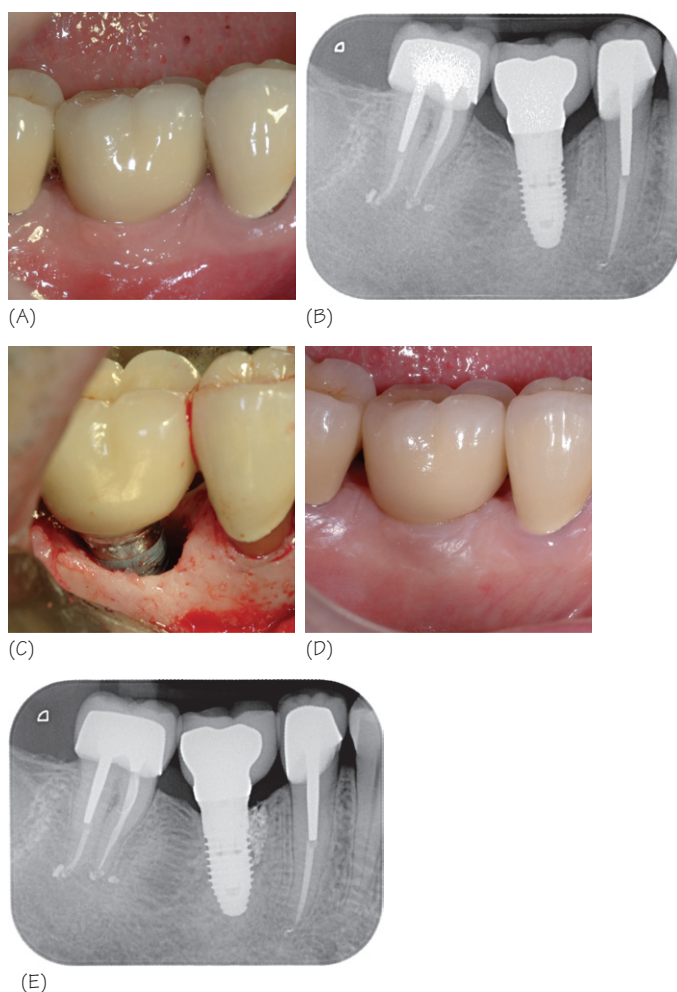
Radiographic interpretation of bone loss around dental implants.
